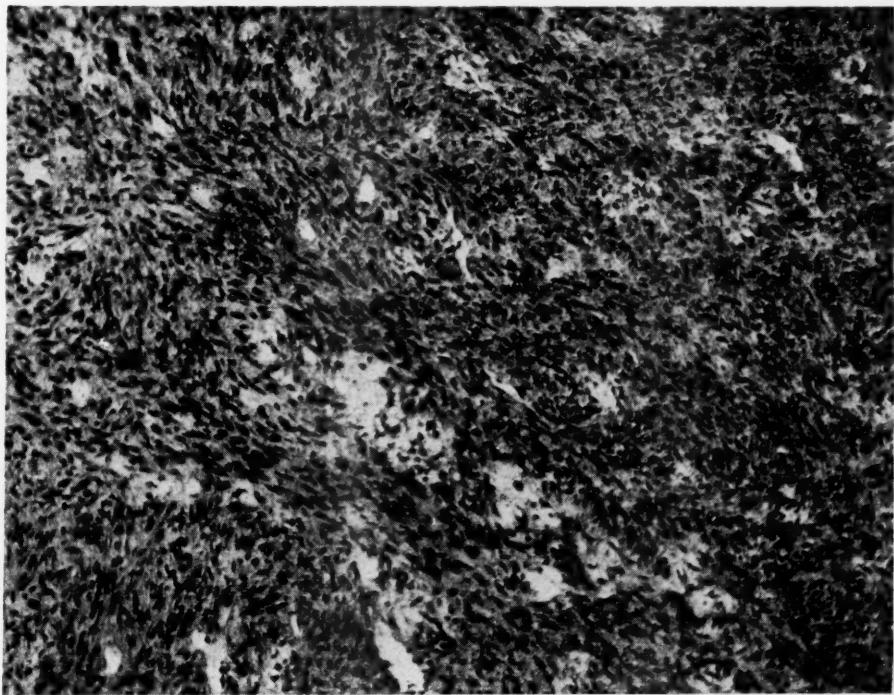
Case 15. Myosarcoma of uterus in patient aged 52 years, seven years after x-ray irradiation of myoma.
